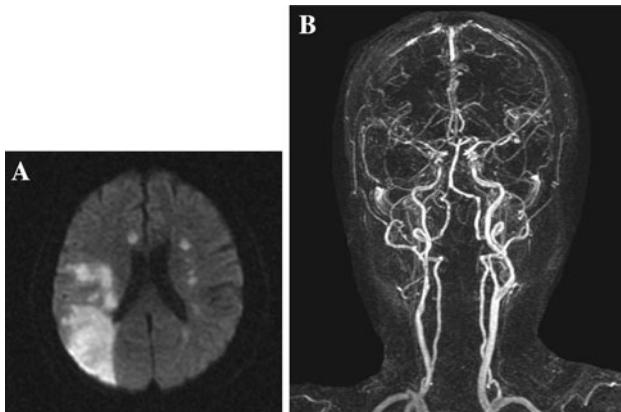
Brain MRI of a 68-year-old hypertensive woman with acute consciousness disturbance, gaze deviation to the right, and bilateral limbs paralysis on the fourth day after aspirin prescription. She had marked drop of hemoglobin (9.2 to 4.3 g/dl). a Diffusion-weighted imaging (DWI) revealed acute bilateral MCA internal borderzone and right posterior borderzone infarcts. b Brain and neck MRA with contrast showed intracranial bilateral MCA and distal VA stenosis, and extracranial right internal carotid artery (ICA) mild focal stenosis
